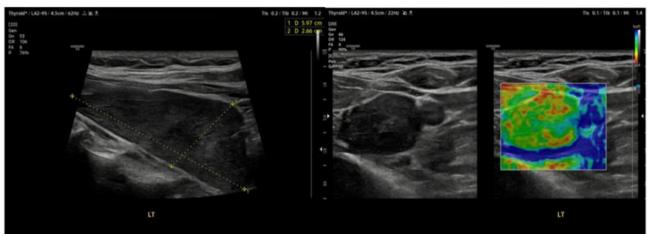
Preoperative neck ultrasound images showing the hypoechoic mass at the inferior aspect of the left thyroid lobe.
